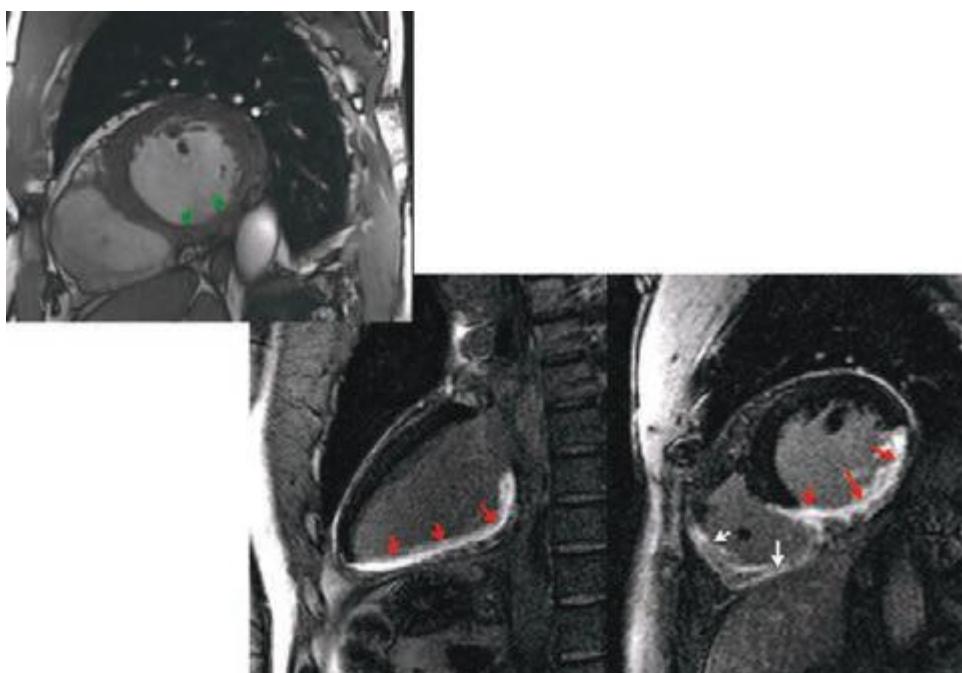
10 A case of viability assessment in a patient with inferior myocardial infarction. The cine movie in the upper panel shows an area of inferior akinesis (green arrows). Magnetic resonance image demonstrates transmural contrast enhancement of the inferior wall (red arrows) and the right ventricle (white arrows), which is consistent with infarction. Imaging the heart 10–15 min after injection of gadolinium allows for the accumulation of gadolinium in infarcted tissue (red arrows), which identifies nonviable infarcted myocardium as bright. Viability assessment, as in this case, can provide guidance for any benefits of invasive coronary intervention. In this case, the inferior wall is nonviable. Apart from the inferior wall infarction (red arrows), there is extensive right ventricular infarction (white arrows). (See Video 271e-7.)
